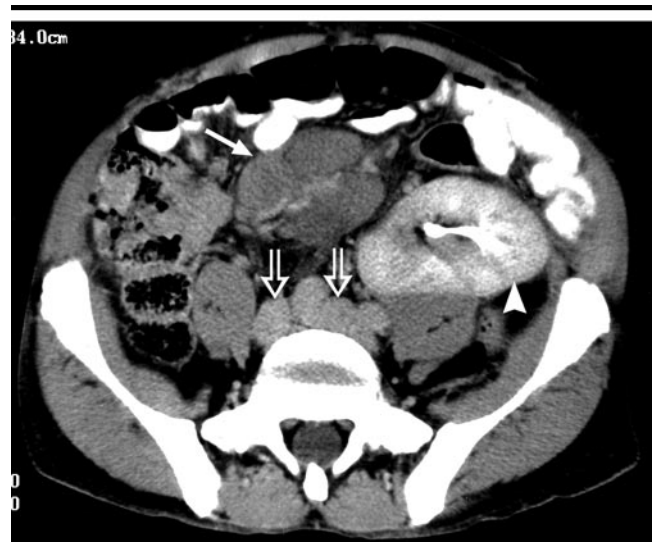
Transverse CT image obtained with oral and intravenous contrast material in a patient who underwent left pelvic renal allograft transplantation 6 months earlier and now has mesenteric post-transplantation lymphoproliferative disorder (PTLD). Mesenteric lymphoma mass (solid arrow) just to the right of the pelvic kidney (arrowhead) has produced a sandwich sign. Retroperitoneal lymphadenopathy (open arrows) is also seen.
